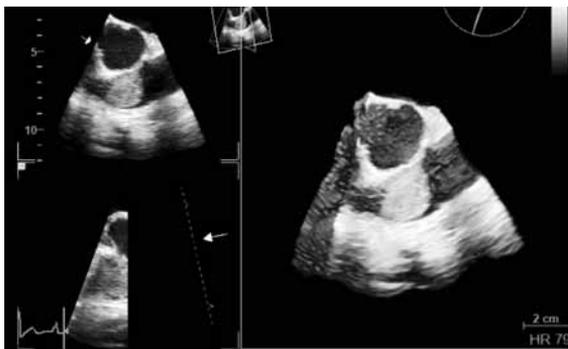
Live three-dimensional transesophageal echocardiography image of the myxoma below the pulmonary valve.
